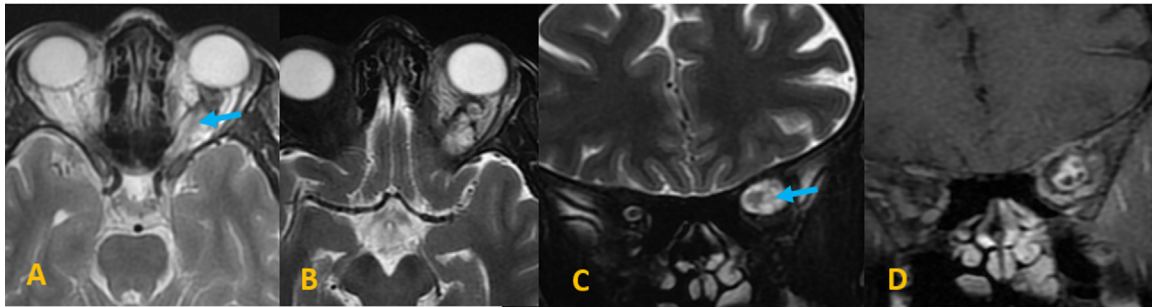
Orbital MRI after one year of follow-up. A small retro-orbital residual process (blue arrow) with high signal on T2 weighted ponderation (A, B, and C) and a heterogeneous enhancement (D).
